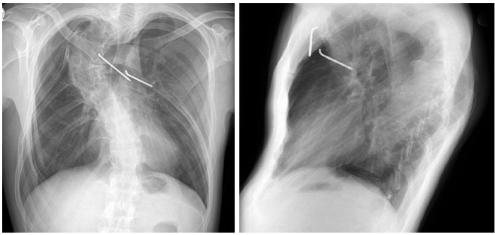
X-rays showing superior mediastinal placement of K-wires.
